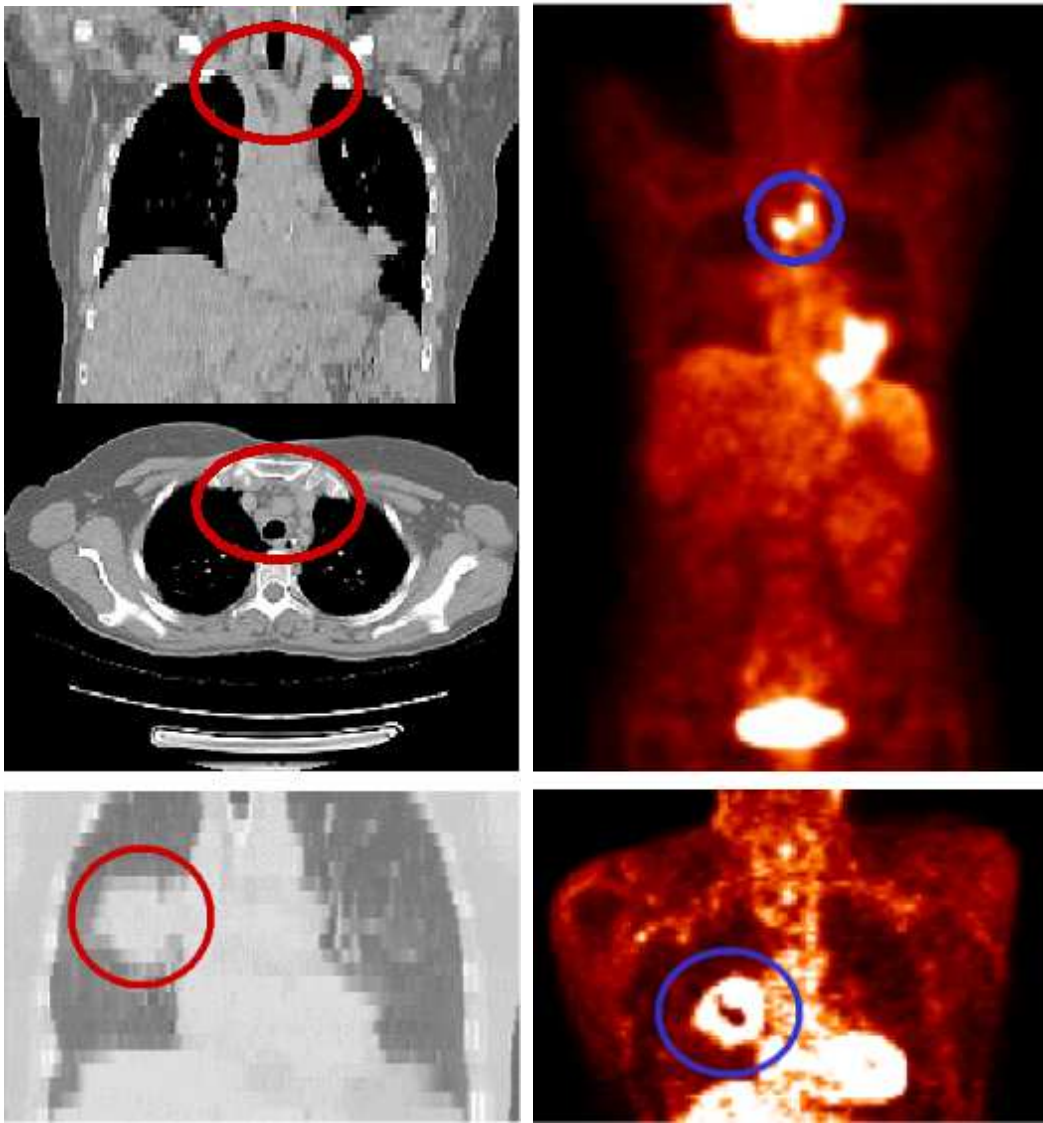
Two examples in which a combination of anatomical and functional information provided by CT (left) and PET (right) images could be useful. A circle defines tumoral regions in each image. Top images: patient 1. Bottom images: patient 2.
